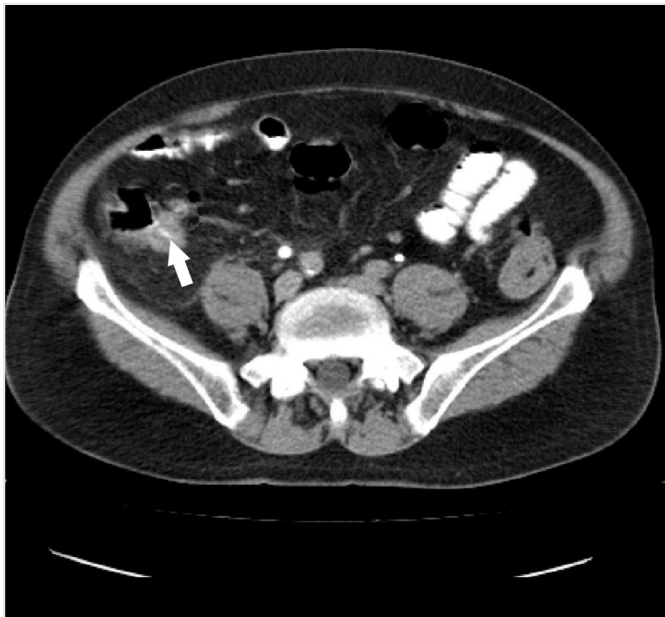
Computed tomography image of the appendix
